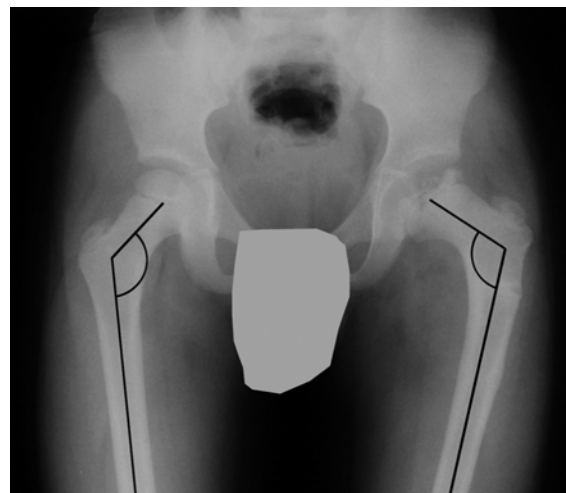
AP radiograph of the hips showed neck-shaft angle
